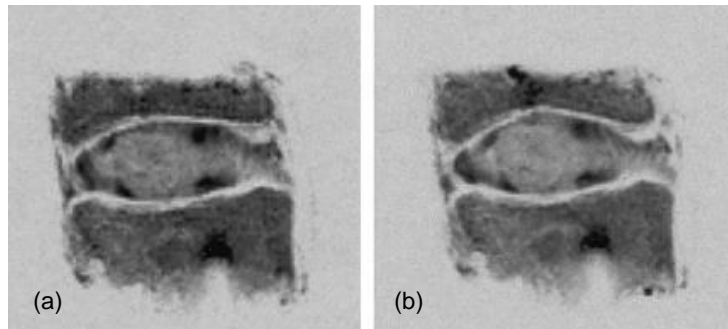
MRI images from Meakin *et al.*'s study (2001) showing an *in vivo* disc in its unloaded (a) and compressed (b) states. With compression, the nucleus and layers of the annulus are seen to bulge radially.
